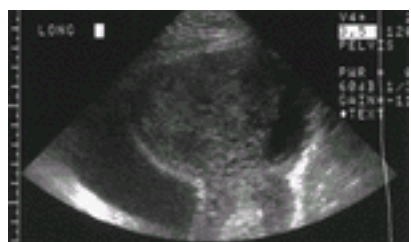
Ultrasonographic image of a tuboovarian abscess.
